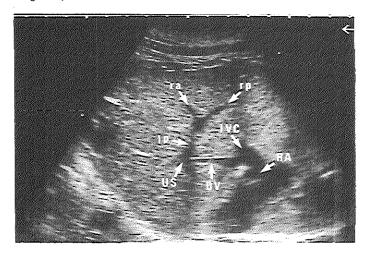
Ultrasonic image from a normal human fetus at 36 weeks of gestation in a transverse to oblique scanning plane. Landmarks are the anteriorly situated umbilical sinus (US) and the left portal vein (Ip).
